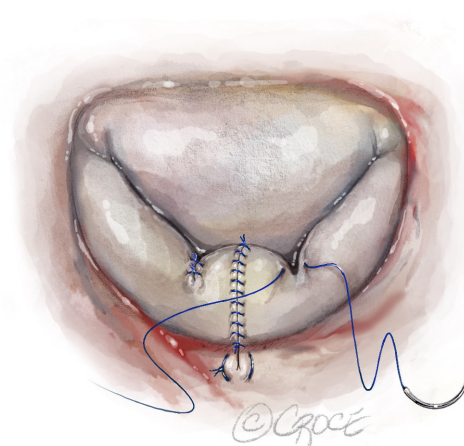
Leaflet closure is performed in two layers with running 5-0 braided sutures, though Prolene is acceptable. The first layer is full-thickness, and the second smooths the leaflet surface at the coaptation zone to minimize small residual jets. If trivial or mild MR appears on post-repair TEE, confirm the jet originates from the coaptation zone and not the suture line. Surface jets are typically stable, with no effect on long-term durability, but a mid-body suture-line jet can enlarge and should be repaired with a small pericardial patch. After resection, segmental indentations (P1–P3) may widen; clefts extending >50% toward the annulus are routinely closed (~80%) to prevent jets and ensure even chordal tension. This method achieves <mild MR in 94% of intraoperative TEEs. MR, mitral regurgitation; TEE, transesophageal echocardiography.
